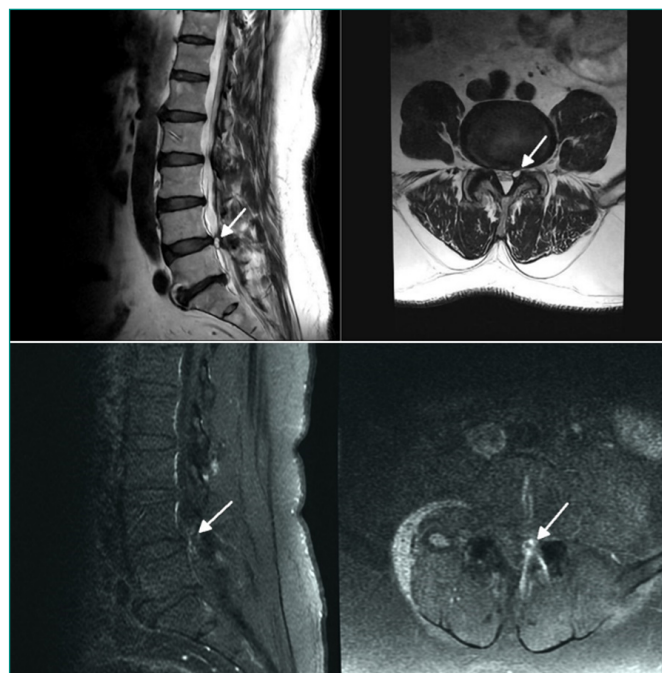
Microphotographs show T2-weighted MR axial images (1A) and T1-weighted MR axial images with gadolinium of a patient with a facet cyst.
